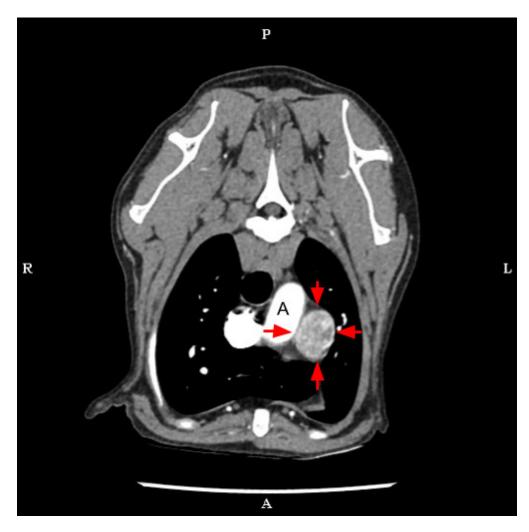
CT image (post-contrast, arterial phase, soft tissue window) of the heart base mass (arrows). A: aorta.
